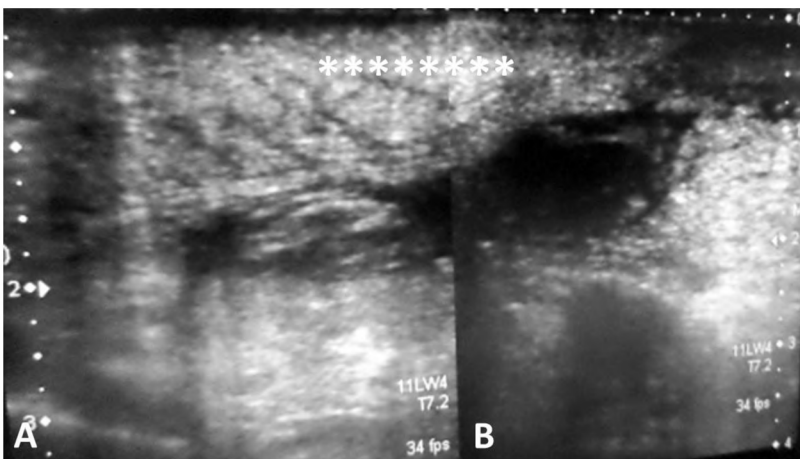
Cellulitis (A&B) Sonography images showing the marked diffuse parietal edema due to cellulitis (\*\*\*\*\*).
